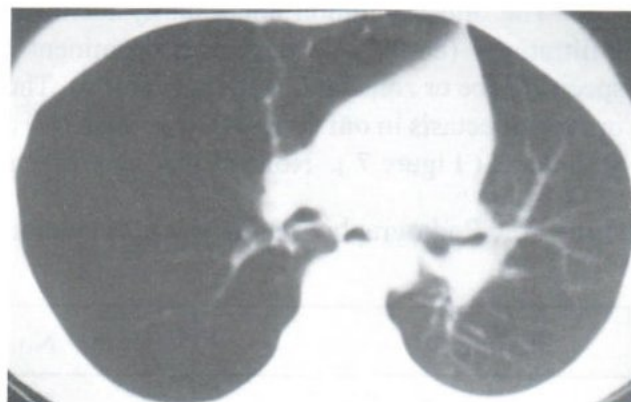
CT scan confirms obstructive emphysema of the right lung with contra-lateral herniation of right lung across the anterior mediastinum.
